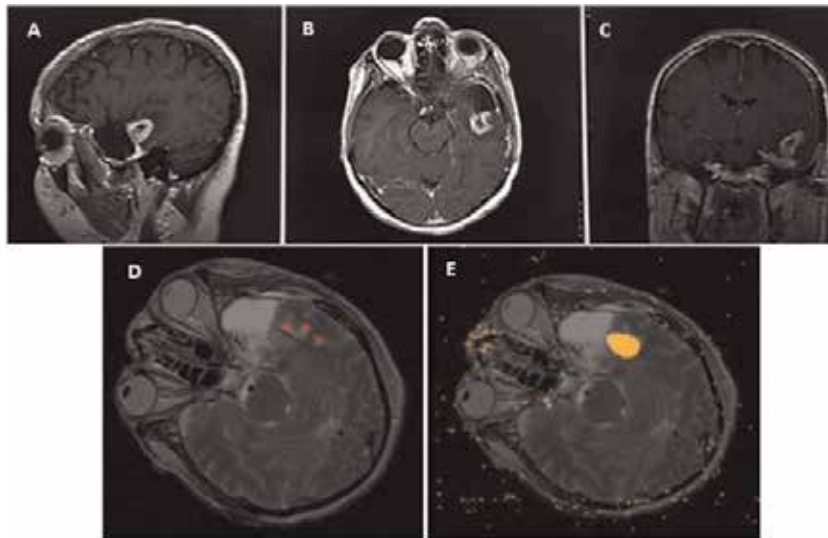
Representative results of MR thermometry, which acquires real-time temperature data for each pixel of an M2-weighted MRI image. Representative preoperative sagittal (A), axial (B), and coronal (C) T1-weighted MRI with contrast images are suggestive of high-grade glioma. In planning a course of LITT, markers for temperature thresholds to achieve ablation while avoiding off-target damage or tissue vaporization are set by the user (D). During LITT, a damage zone of tissue achieving temperatures sufficient for ablation is represented by orange pixels (E).
